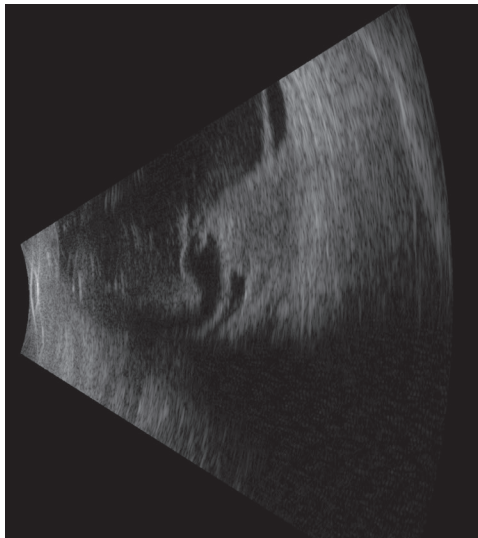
Ultrasound of the right eye revealing an exudative retinal detachment, vitreous hemorrhage and a mushroom-shaped, centrally echolucent choroidal mass, concerning for uveal melanoma.
